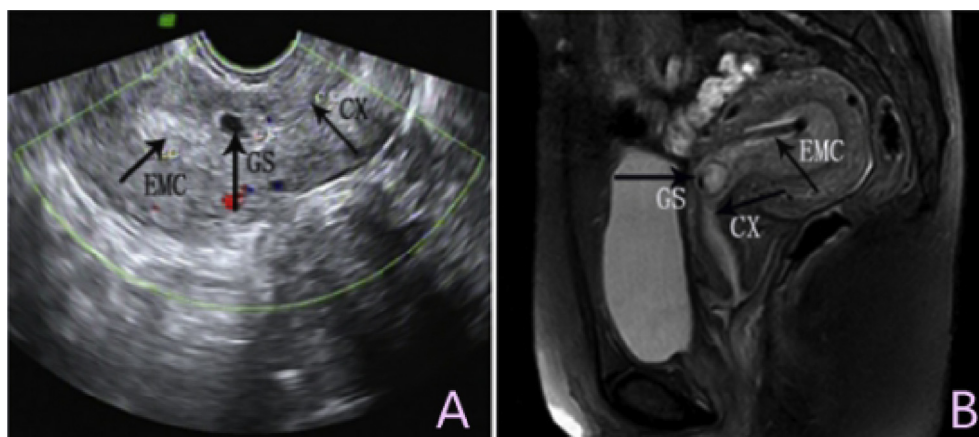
(A) Transvaginal ultrasonography shows a gestational sac (GS) in the lower anterior uterine wall with an empty endometrial cavity (EMC) and cervical canal (CX). (B) Magnetic resonance image shows a gestational sac implanted in the anterior wall of the uterus, and protruded into the uterine cavity.
